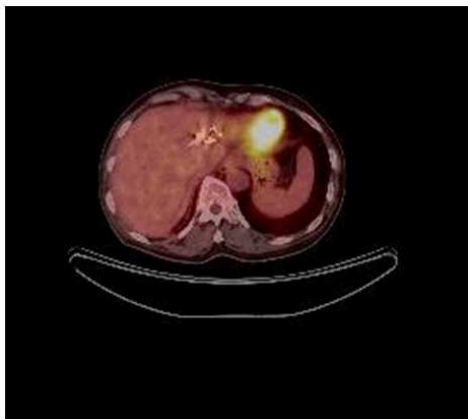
Postoperative PET-CT scan shows no tumor recurrence at left superior hepatectomy location.
